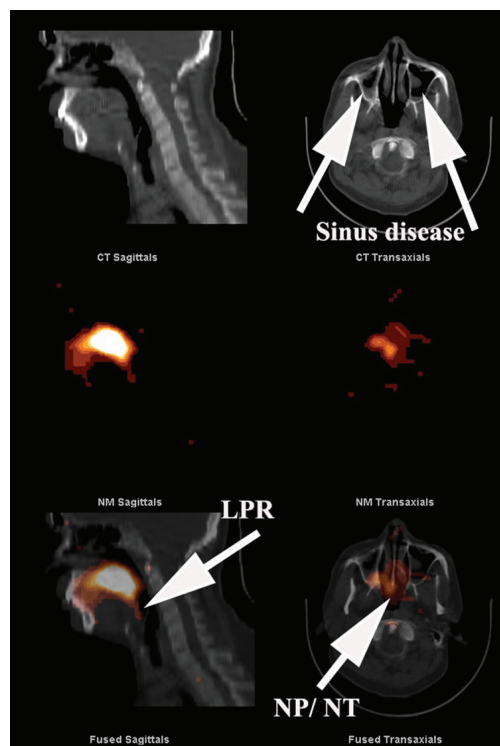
SPECT/CT image of head and neck. The upper panel of CT images with evidence of polyposis of both maxillary sinuses consistent with sinus disease. The fused images in the lower panel demonstrate evidence of LPR as well as contamination of the NP, NT and both maxillary sinuses. The central panel shows the scintigraphic images from the region in the absence of anatomical landmarks
